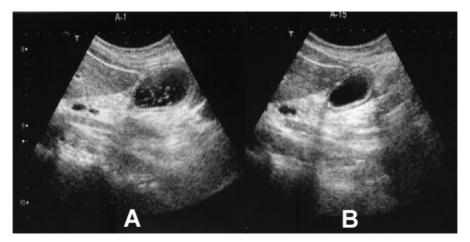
Ultrasound assessment of gastric emptying rate
